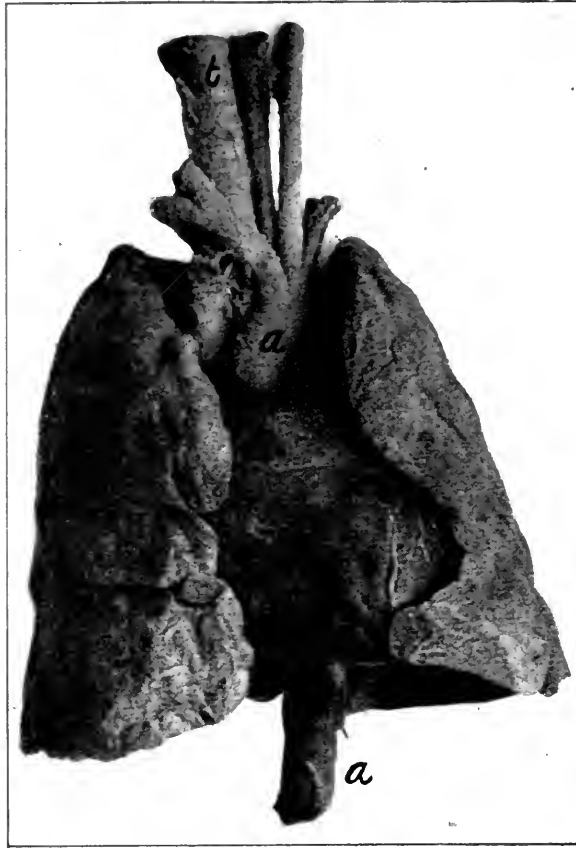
PHOTOGRAPH OF HUMAN HEART AND LUNGS FROM VENTRAL ASPECT.
